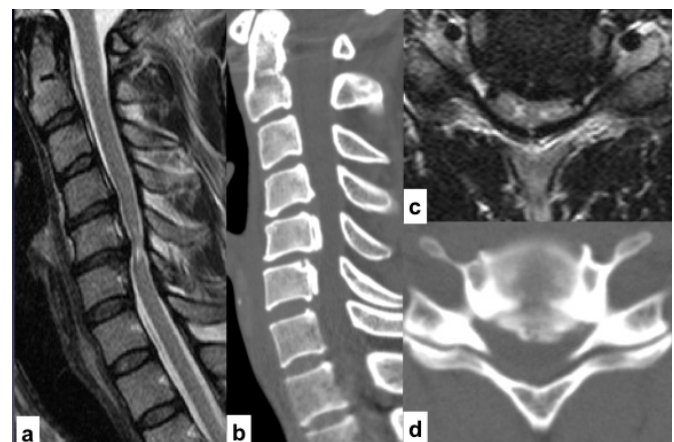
MRI showing severe stenosis especially in C5-C6 and intraaxial signal change (A and C) CT demonstrating ossification of longitudinal ligament in C5-C6 level.
